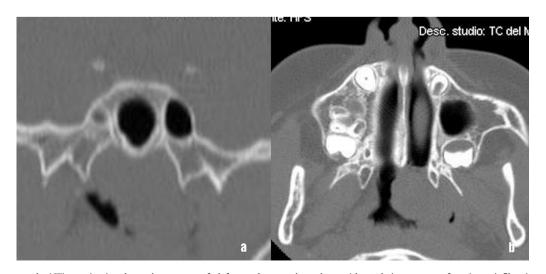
Computed tomography (CT) examination shows the presence of a left nasopharyngeal neoplasm without obvious aspects of erosion or infiltrations of the surrounding structures, especially the left medial pterygoid process.
